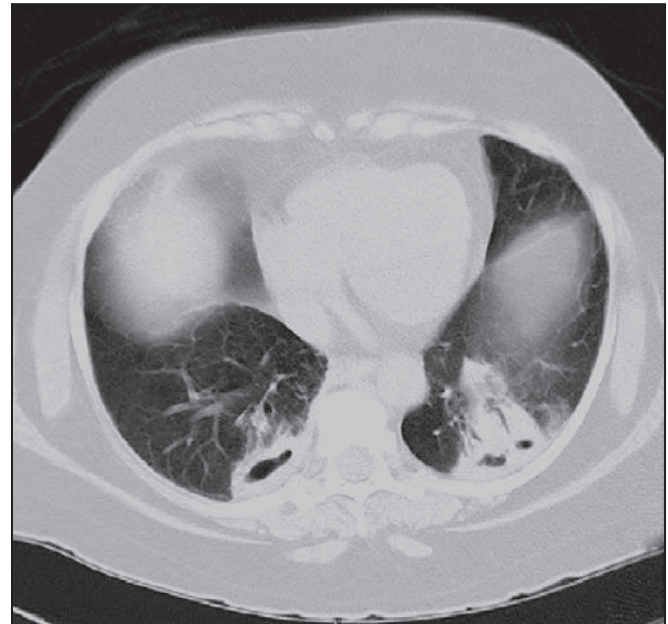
Axial computed tomogram of the chest in patient 3 showing bilateral cavitary focal disease with underlying fibrosis.
